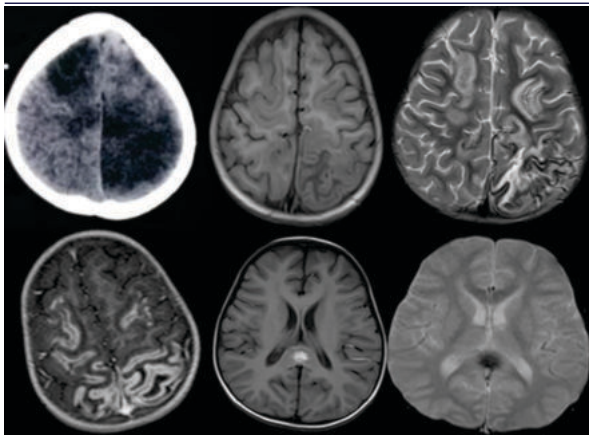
Axial CT shows perivenricular calcifications. MRI showing T2/FLAIR subcortical hyperintensities in frontal and parietal region with few subcortical tubers-Tuberous sclerosis in a 11 year male child.
